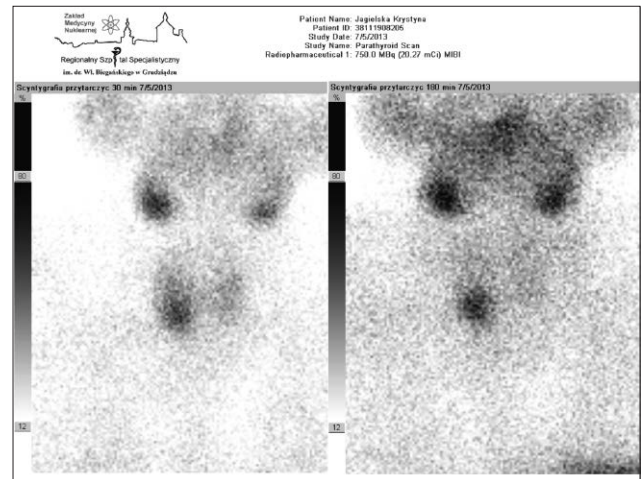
A two-phase scintigraphy with the use of $^{99\text{m}}\text{Tc}$ -sestamibi (30 and 180 minutes after radioactive marker administration).
